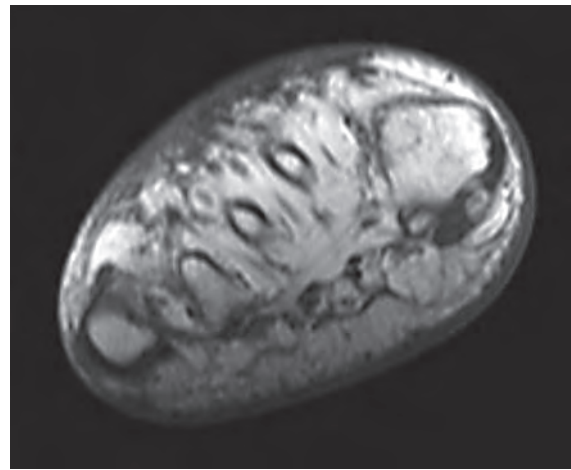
Magnetic resonance imaging showing subcutaneous edema.
